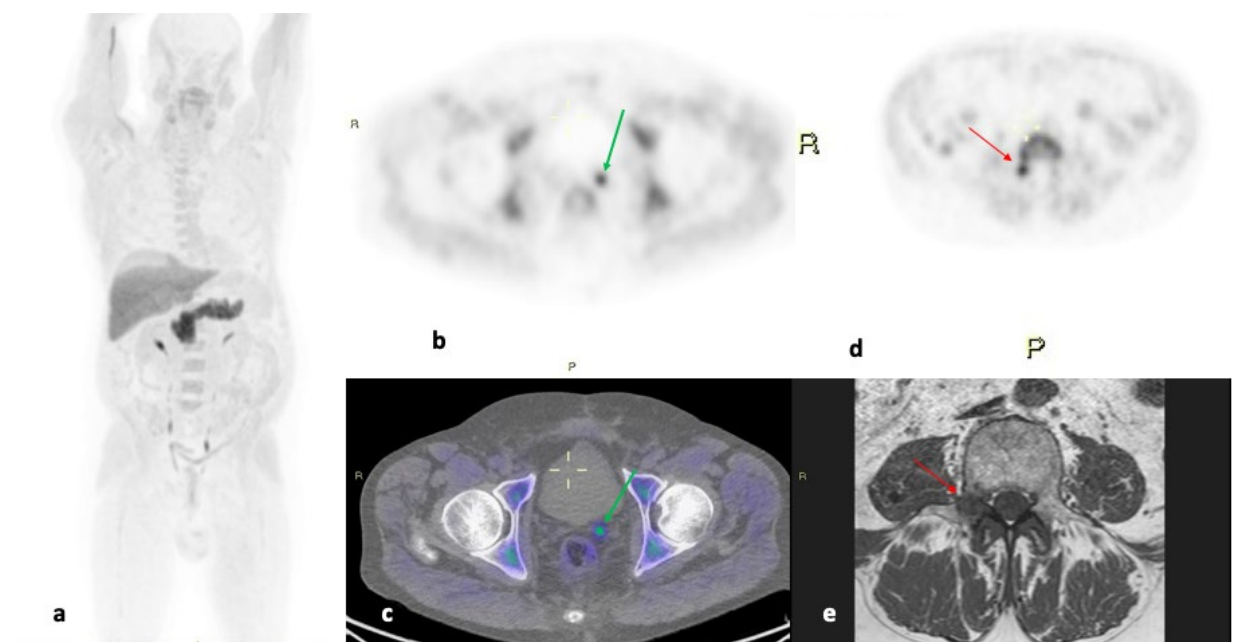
Maximum intensity projection (a), [¹⁸F]Fluciclovine PET (b), and PET/CT (c) axial view of locoregional recurrence of Pca (green arrow), as seen in our series in a patient (61 yo). This recurrence occurred 6 years after radical prostatectomy, PSA 1.34 ng/mL. In (d), a bone focus of [¹⁸F]Fluciclovine uptake, interpreted as metastasis, on the right pedicle of L4 (red arrow) in the same patient is shown, which was then confirmed by MR (e).
